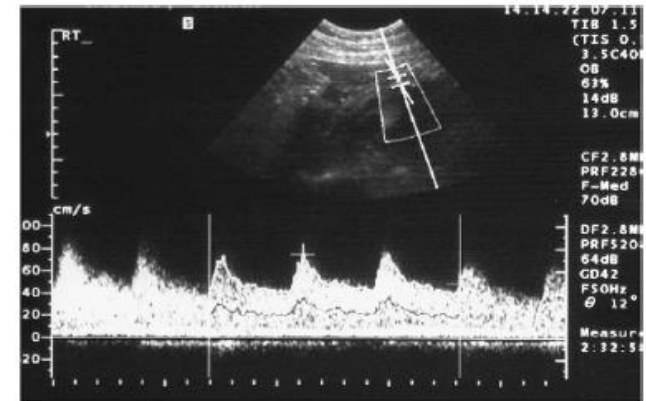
Normal uterine artery Doppler ultrasound.
